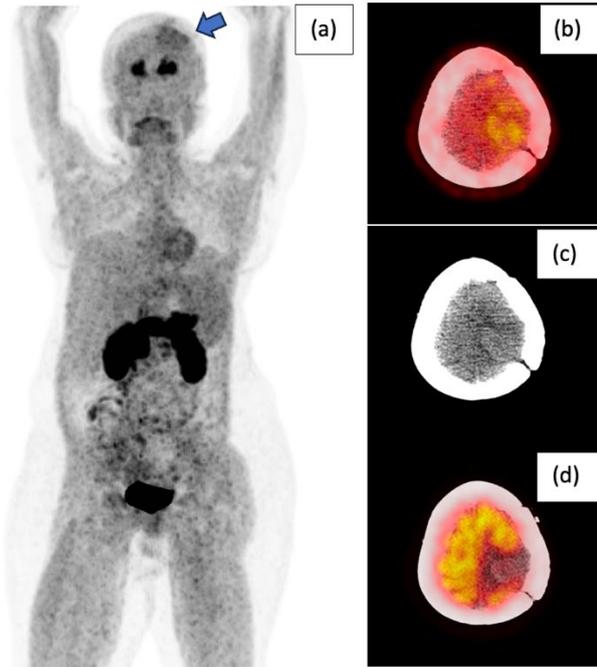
FDOPA PET/CT scan of 21 years old female intracranial neuroendocrine tumor patient (a, blue arrow) shows intense tracer uptake mass in the left frontoparietal (b,c). FDG PET/CT scan shows amebolic mass in the left frontoparietal (d).
